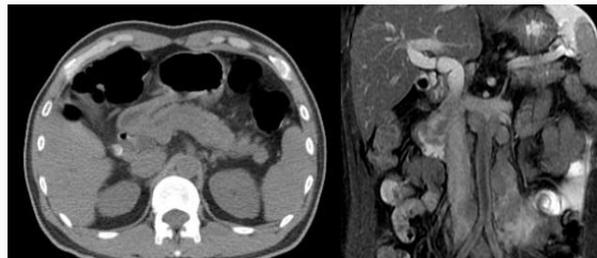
The abdominal CT revealed a protruding mass from CBD and pancreatic duct junction (left). The abdominal MRI showed the duodenal tumor arising from Ampulla of Vaer and several lymph nodes enlargement in paraaortic region (right).
